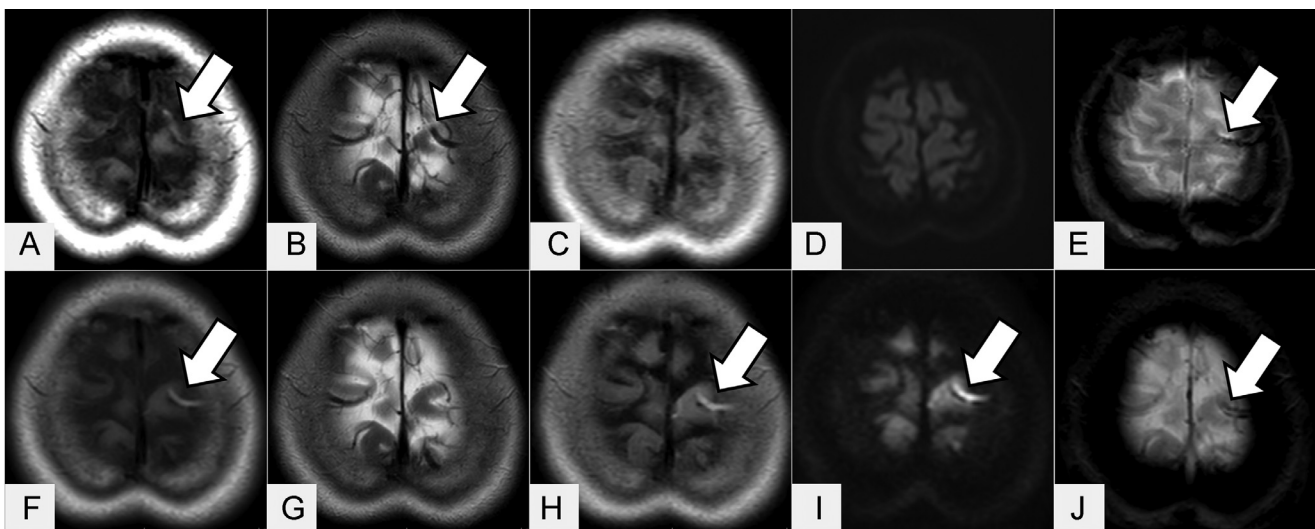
Signal changes in cord sign on the day of onset (upper row) and Day 7 (lower row). On the day of onset, intracranial venous thrombosis (arrows) was detected as high signal intensity on T1WI (A) and low signal intensity on T2* gradient-echo image (E). No signal changes were observed on fluid-attenuated inversion recovery (FLAIR) (C) or diffusion weighted imaging (DWI) (D). On Day 7, no signal changes were observed on T1WI (F) and T2* (J); however, high signal intensity of the thrombus was noted on FLAIR (H) and DWI (I). The thrombus area on T2WI appeared as a low signal intensity on the day of onset (B) but became indistinct on Day 7 (G).
